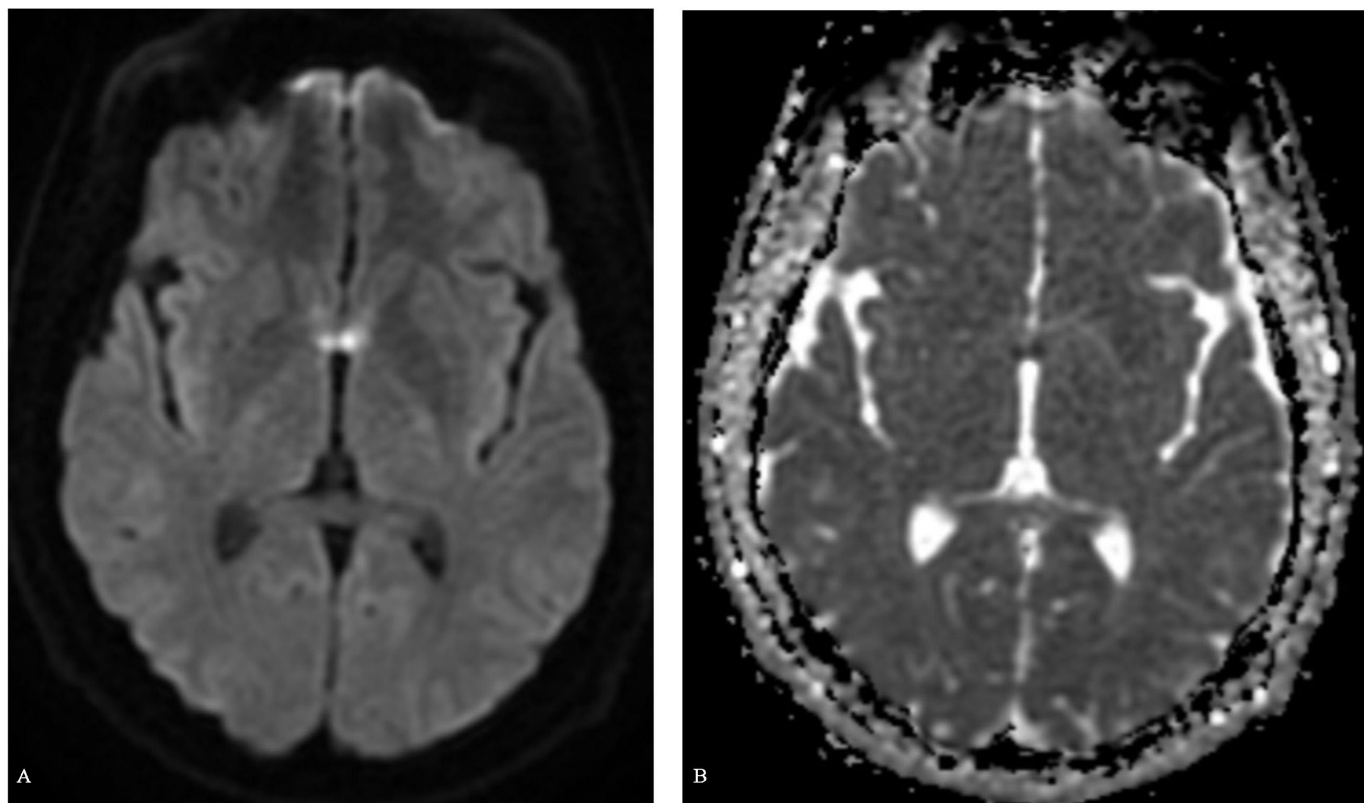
(A) Axial MR diffusion weighted imaging (DWI) and (B) corresponding apparent diffusion coefficient (ADC) showing acute bilateral infarction in the anterior columns of the fornix.
